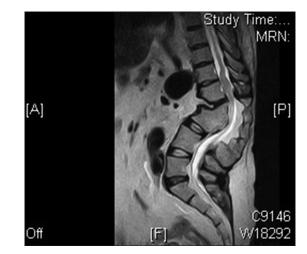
Magnetic resonance imaging of kyphosis showing cord compression
